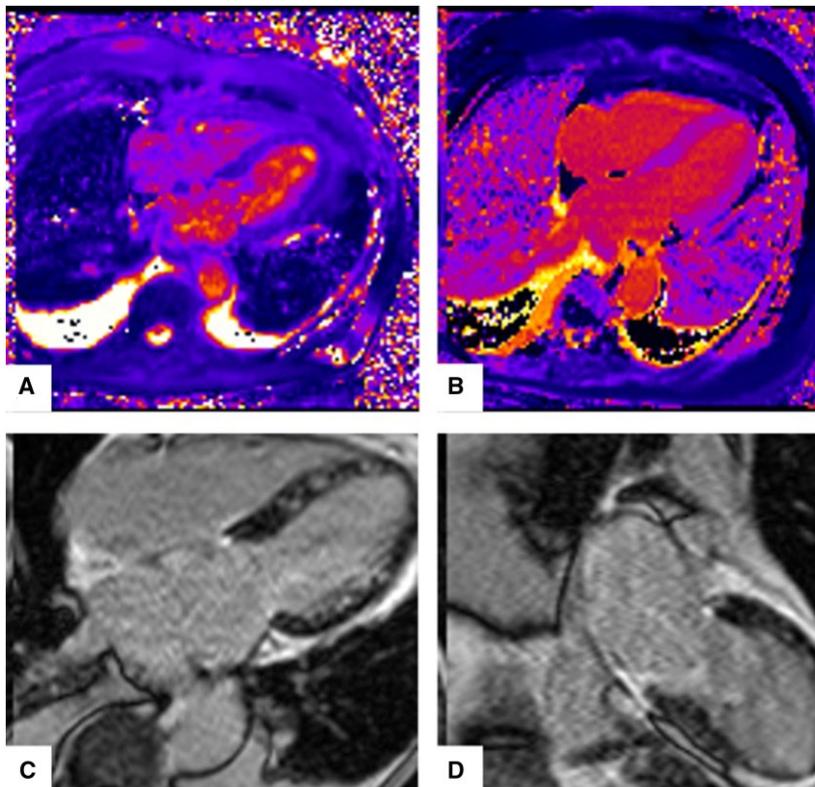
Cardiac magnetic resonance imaging at presentation showing acute myocarditis. (A) Diffuse myocardial oedema on T2 mapping. Mean T2 = 71 ms. (B) Diffuse mid-myocardial fibrosis on T1 mapping. (C, D) Diffuse patchy mid-myocardial late gadolinium enhancement (LGE).
